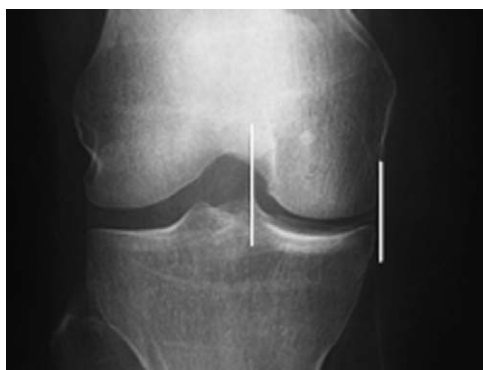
Preoperative anteroposterior radiograph used for meniscal sizing. Meniscal width is measured from the peak of the tibial eminence to the medial tibial metaphyseal margin.
